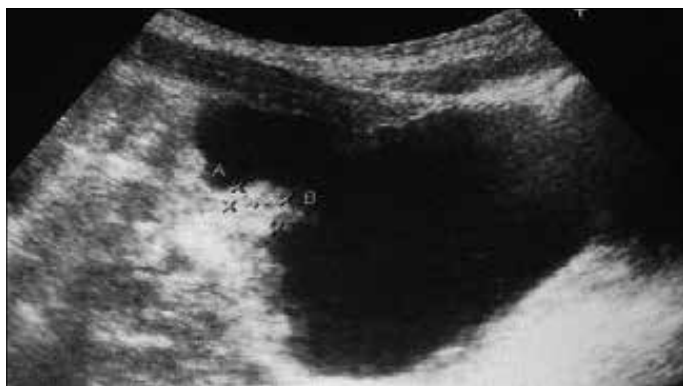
Ultrasonographic view of intravesical nephrogenic adenoma
